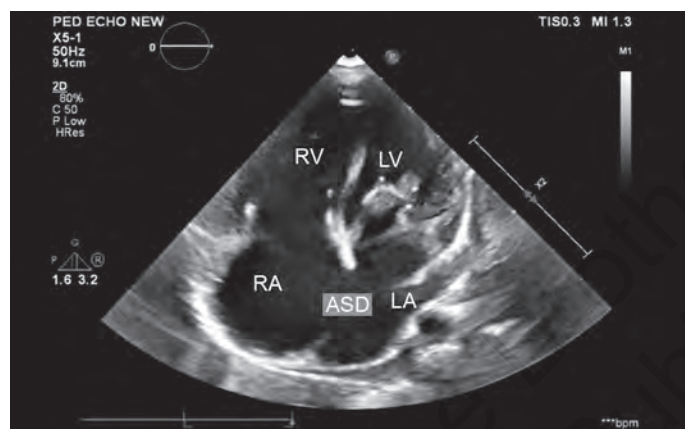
D-TGA: Apical four-chamber view showing large ASD.
